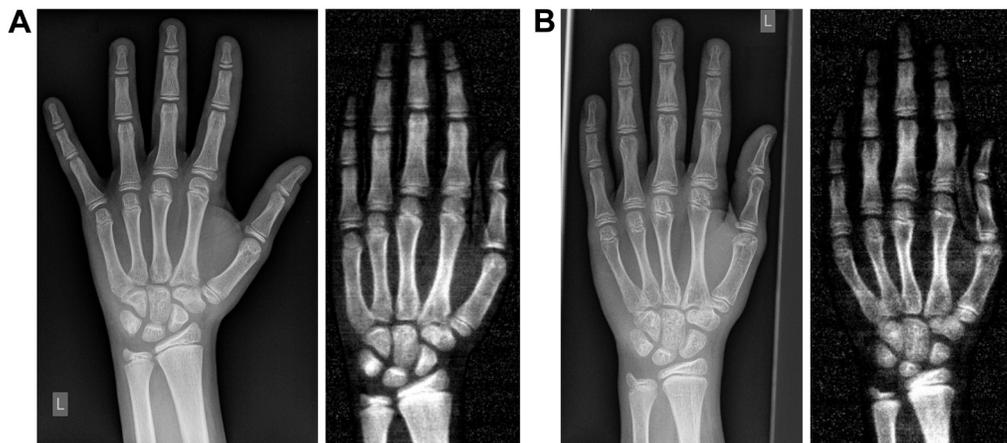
Radiographs (left side) and iDXA pictures (right side) of the left hand of 2 individual trial patients. (A) An eligible pair of images on radiograph and iDXA. (B) A pair of images where the iDXA is not eligible in comparison to the radiograph.
